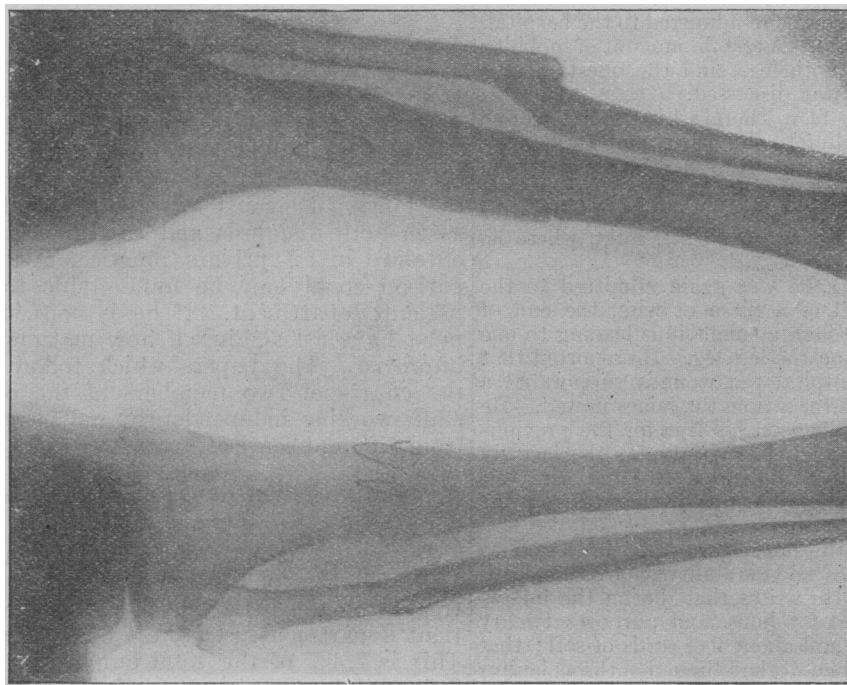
An x-ray photograph, showing the united fractures in the shafts of both bones of both legs. In the right tibia there are two wire sutures, in the right fibula one, and in the left tibia one. There is some displacement of the fragments of the left fibula, but there is good bony union between them.
